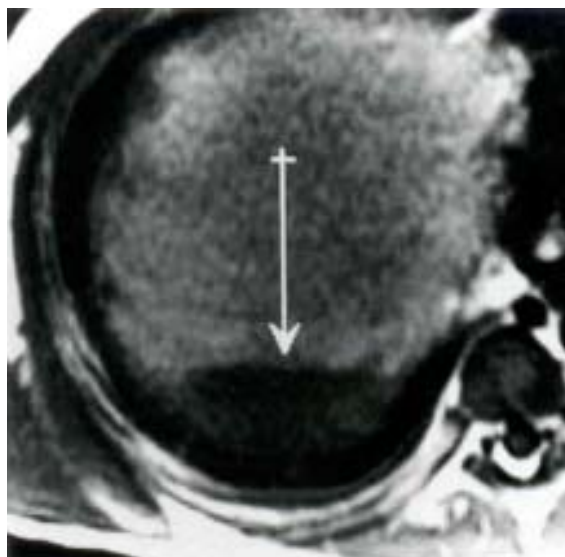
MRI of the liver mass revealing fluid-fluid level (large white arrow) in the lower nonseptate part of the tumor
